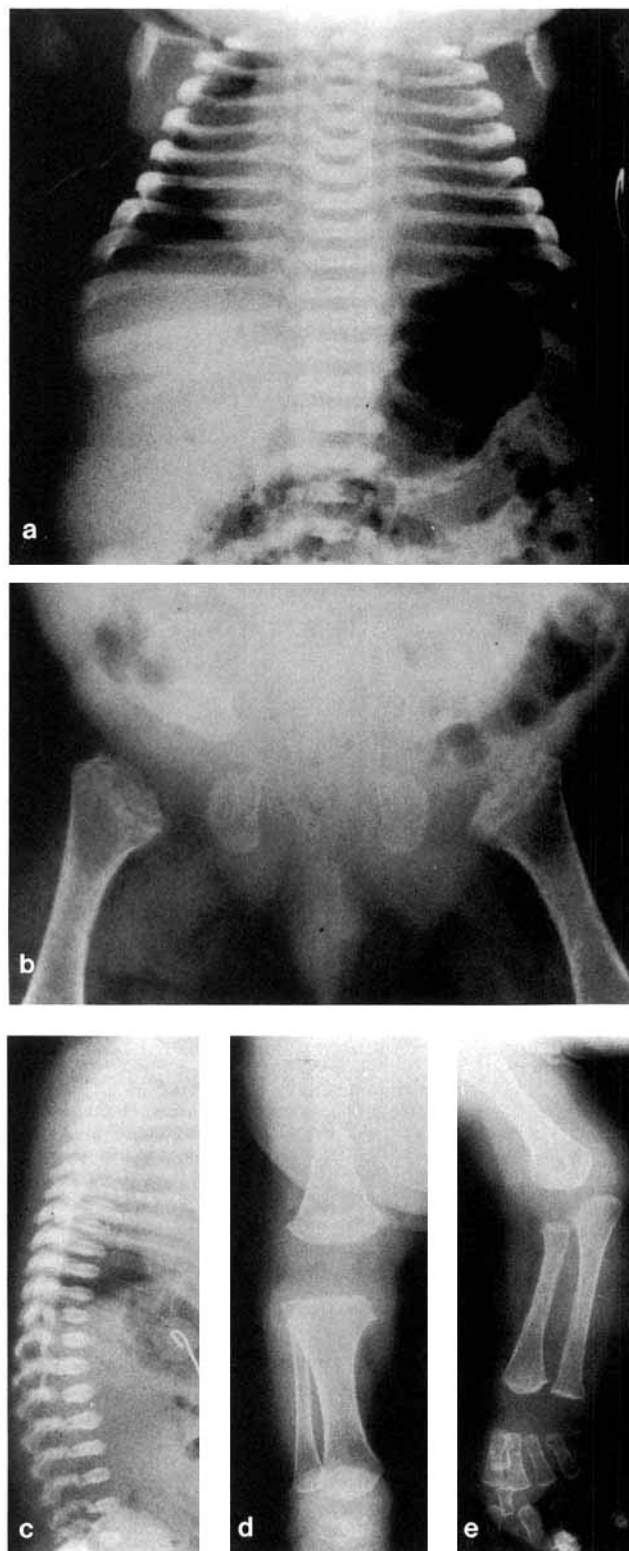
Radiographs of patient 2 at age 3 months, showing short ribs, especially in the upper half of the thorax (a), platyspondyly, and coronal clefting (a, c). The basilar portion of the iliac bones is hypoplastic, and the ischial bones are short and broad. b: There is no ossification of the pubic bones. The tubular bones are short. b, d, e: The metaphyses are large and convex with an irregular border, especially of the upper femoral metaphyses. d: The diaphyses appear relatively broad.
